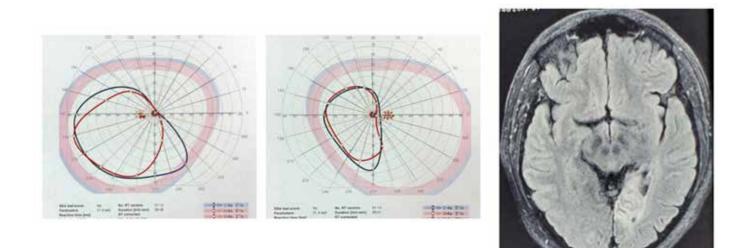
Visual fields of otherwise healthy male patient in his late fifties showing right homonymous hemianopia (a&b). The patient presented with the complains of right field defect 2-weeks following recovery from COVID-19 infection requiring hospitalization. MRI brain revealed left sided occipital lobe infarct (c).
